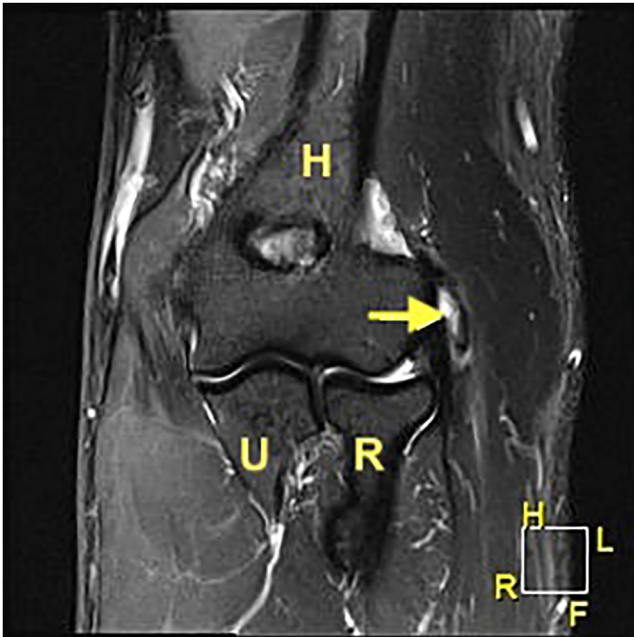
T2-weighted coronal magnetic resonance imaging of the left elbow demonstrates a mildly retracted ECRB tear (arrow) at the lateral epicondyle of the humerus (H). The ulna (U) and radius (R) are at the bottom of the image. (ECRB, extensor carpi radialis brevis.)
